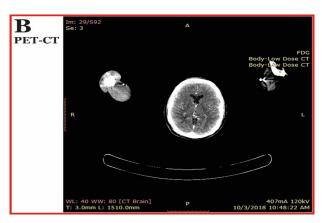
(2018 - PET-CT)
